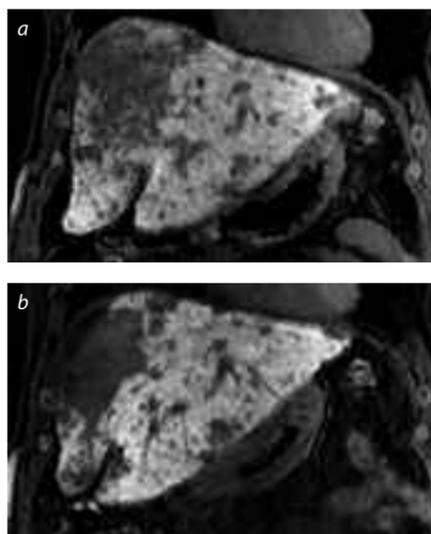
64-year-old male patient with history of alcohol-induced liver cirrhosis and advanced multifocal, multinodular HCC (Child-Pugh A, BCLC stage C). CE-MRI (Gadoxetic acid hepatocytic phase) (a) prior to RE; (b) 3 months after RE (2,2 GBq, approx.  $\frac{3}{4}$  of the dosage to the right,  $\frac{1}{4}$  to the left liver lobe: partial response in terms of reduced number of tumours, reduced perfusion, and secondary hypertrophy of the left liver lobe).
